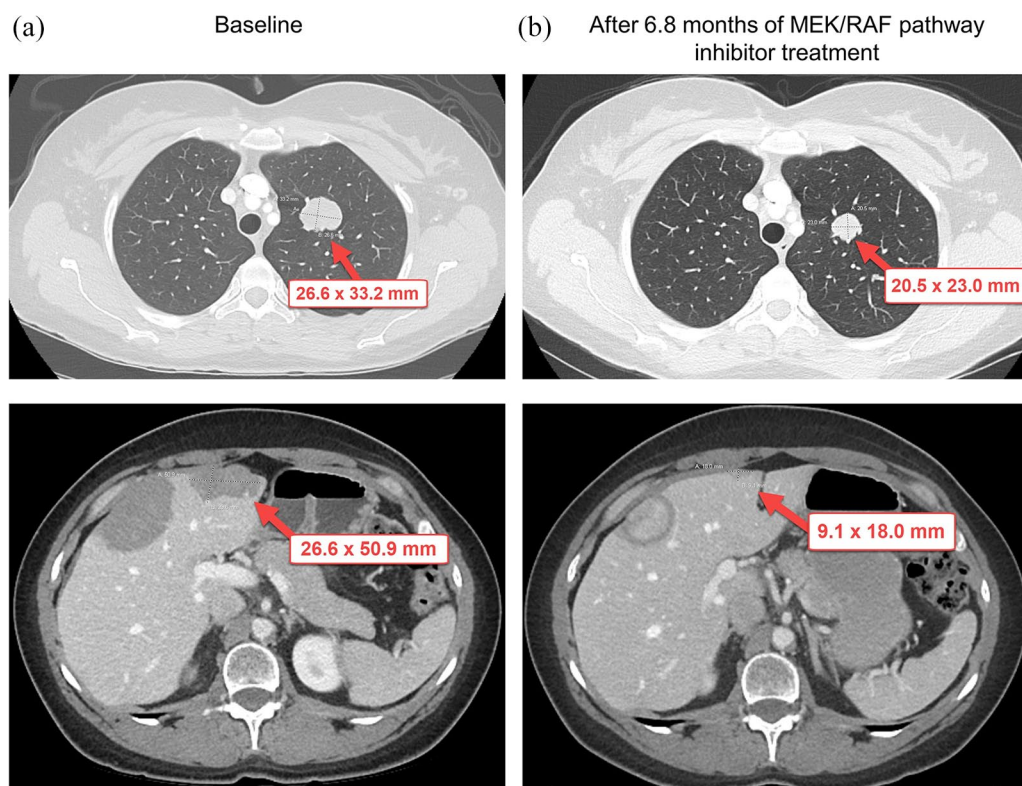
Changes in tumor measurement from baseline in patient 002, who underwent treatment with MEK/RAF pathway inhibitor on the basis of ctDNA analysis showing *RAF1* amplification. (a) Representative computed tomography (CT) images from the patient at baseline. (b) Representative CT images from the patient after 6.8 months of treatment with MEK/RAF pathway inhibitor. Red arrows indicate target lesions.
